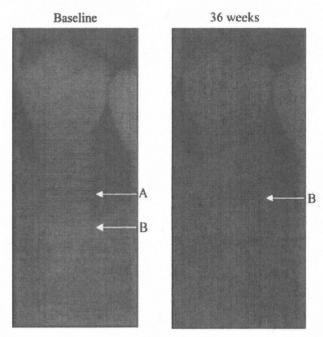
Radiographic outcome of a FGF-2-administered individual. A 0.3 % FGF-2-administered 39-year-old woman. The arrows indicate the remaining alveolar bone crest or the bottom of the bone defect. The depth of the intraosseous defect before administration was measured at 3.0 mm on the x-ray. The radiographs clearly show that the bone defect was filled with the newly generated alveolar bone at 36 wks after administration. The percentage of bone fill at 36 wks was 69.14%, with 3 mm CAL regained.
